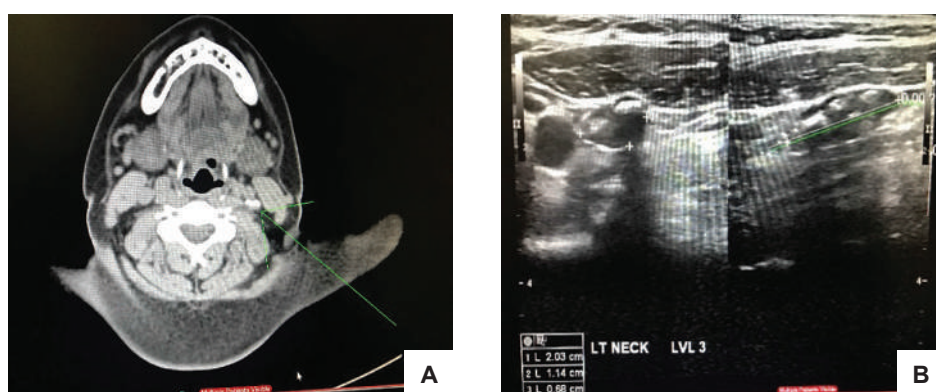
(A) CT scan of the neck with contrast. Calcification in the left infrahyoid carotid space possibly calcified lymph nodes. (B) Neck ultrasound. Nodes with calcifications in the left parajugular region (level 3).
